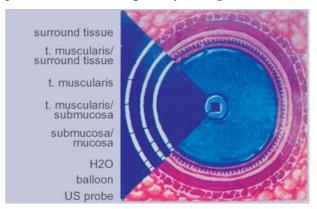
Endosonographic layers of the rectal wall
